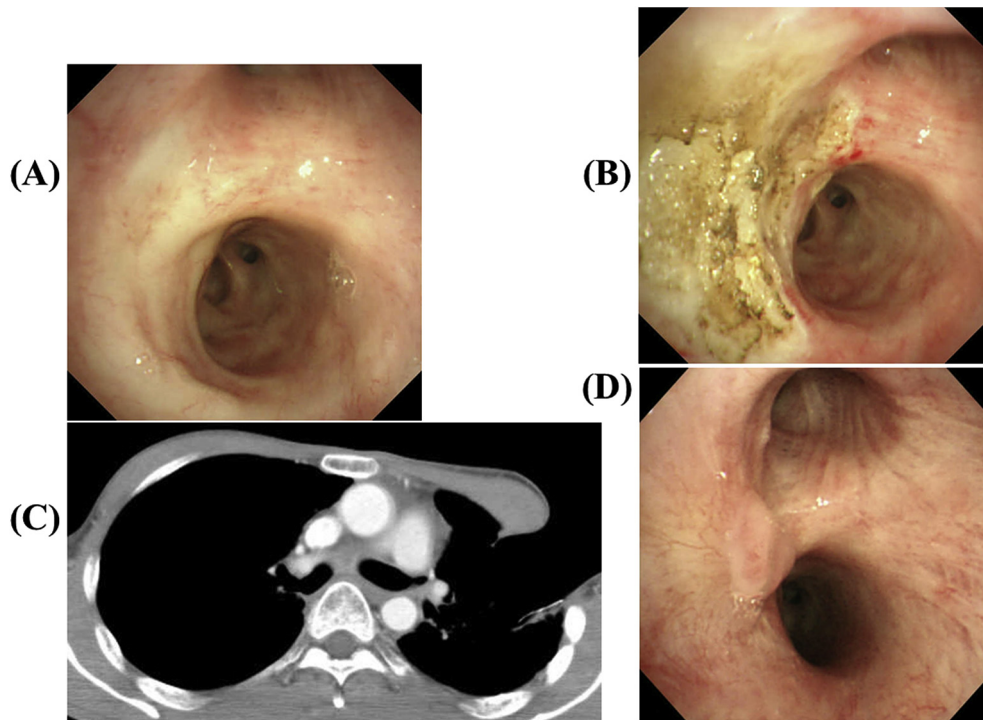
Images of fiberoptic bronchoscopy (FOB) obtained on day 22 of the 4th cycle before (A) and after (B) treatment by argon plasma coagulation (APC) are shown. A scar-like lesion was observed (A), and APC was conducted by using appropriate settings (B). Images of chest CT (C) and FOB (D) obtained 24 months after the APC are shown. Chest CT showed the postoperative status of the left cavernostomy and no abnormalities in the right mainstem bronchus were found (C). A scar-like epithelial thickening was observed by white-light bronchoscopy (D).
